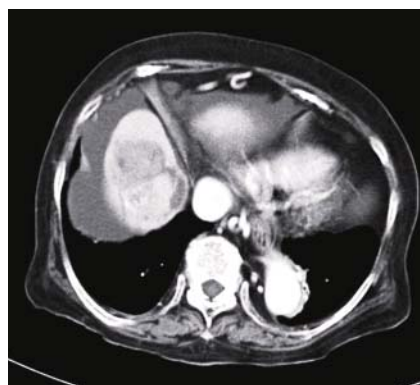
Contrast-enhanced computed tomography showing a hypervascular, in part, necrotic tumor in the right anterosuperior segment of the liver and ascites.
